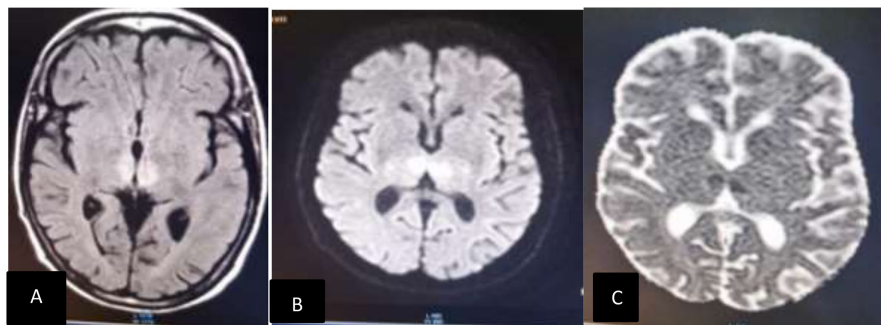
Brain MRI showing hyperintensity on FLAIR sequence (A), hyperintensity on DIFFUSION sequence (B), and restriction on the ADC map (C).
